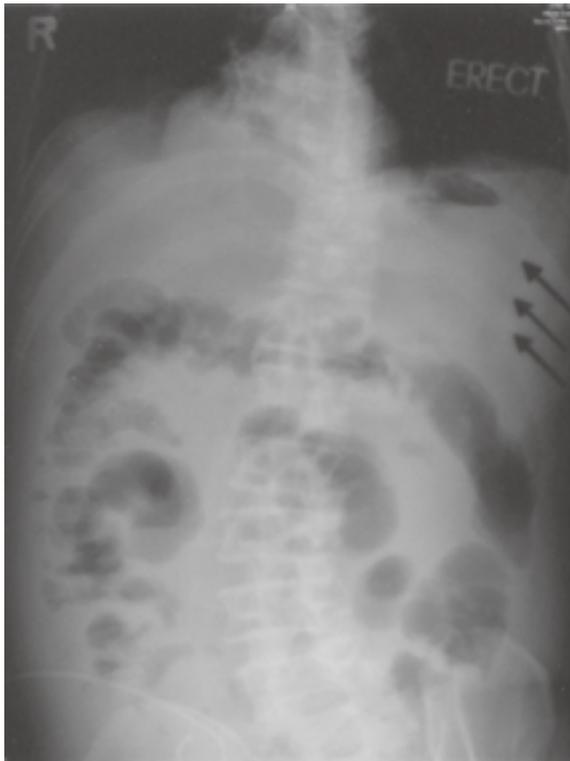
Abdominal radiograph shows an air-filled level in the stomach, with a subtle rim of intermediate low density around a well-defined bezoar (arrows).
